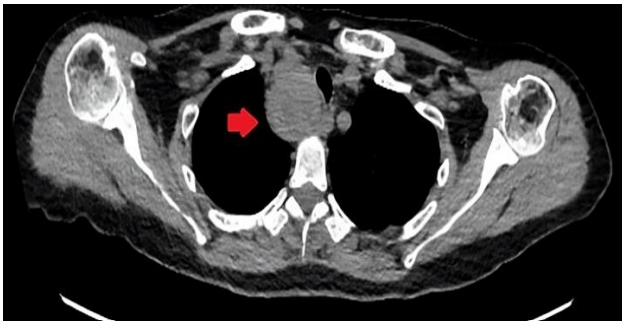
Cervical CT without contrast–Axial view (the red arrow indicates the mediastinal mass) (reprinted with permission of patient)
